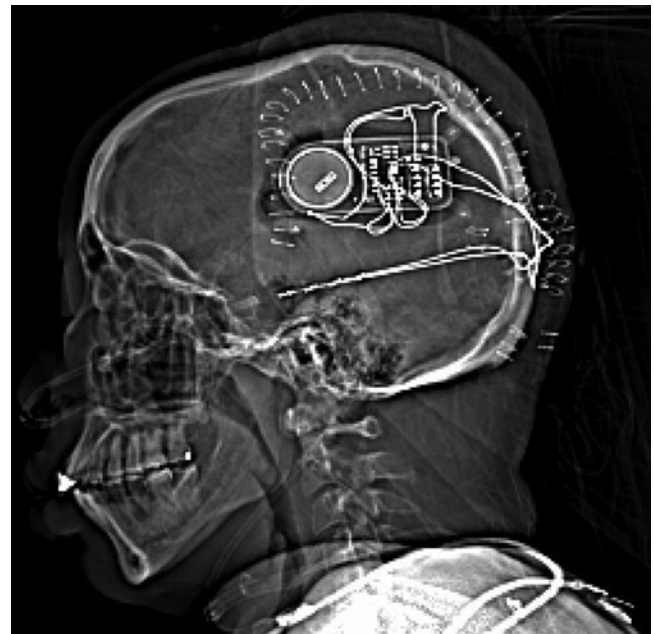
NeuroPace RNS Device. This scout CT scan shows the closed-loop RNS device implanted in a patient with medically refractory epilepsy. The IPG is fixed in the skull, with penetrating depth electrodes extending into the hippocampi bilaterally. Surgical staples can also be seen surrounding the scalp flap. Image provided by Dr. Rosana Esteller, NeuroPace, and Dr. Robert Gross, Emory University.
